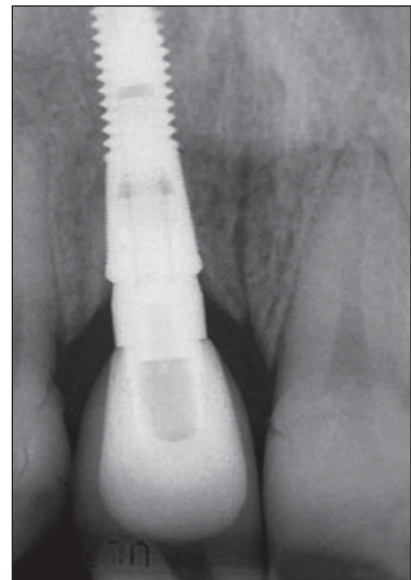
Radiographic evaluation of the implant-bone relationship 3 years following implant placement.
